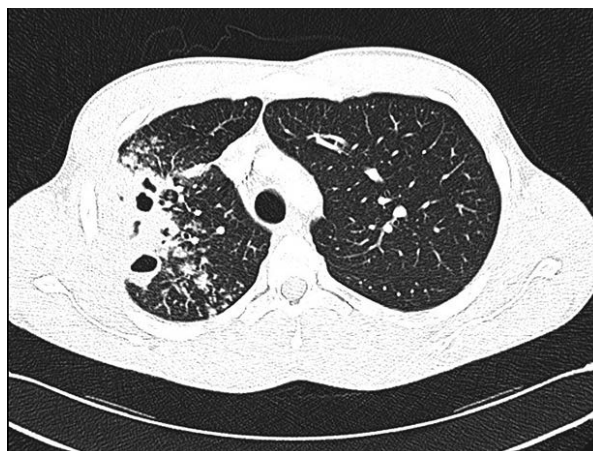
Chest CT. New cavitary lesions in the second right segment
